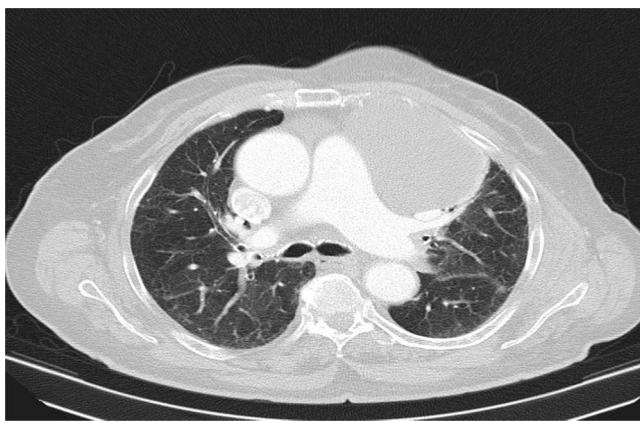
Chest computed tomography, showing cystic lymphangioma in the anterior mediastinum before surgery.
